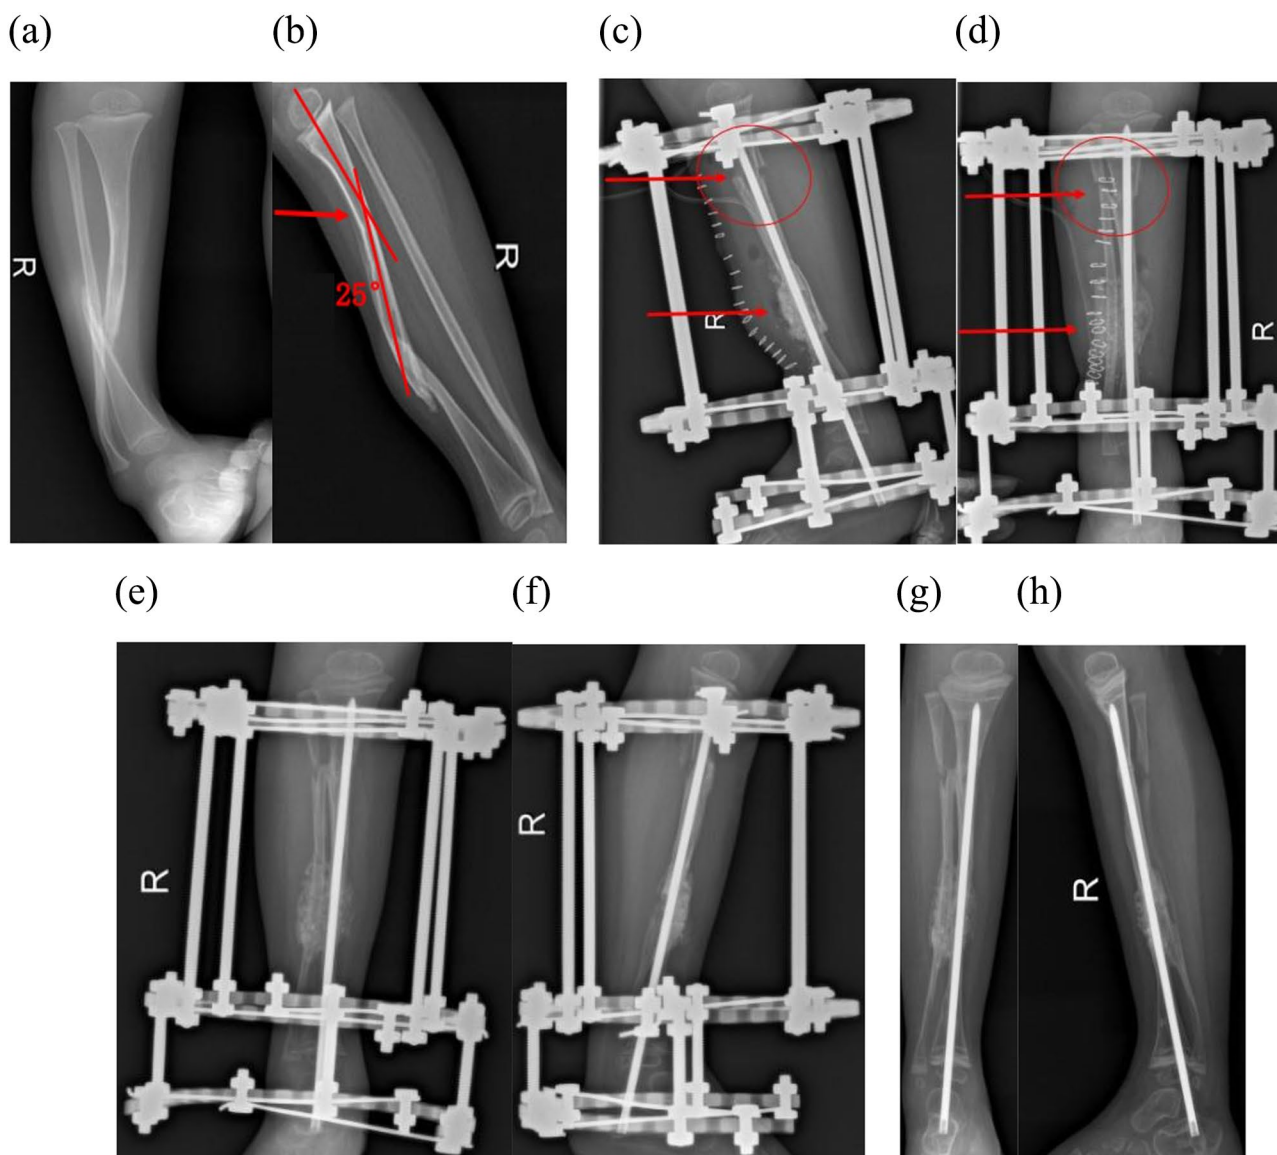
(a, b) CPT with proximal tibial dysplasia, male, 16 months old, preoperative anteroposterior and lateral X-ray. (c, d): One week postoperative anterior and lateral X-rays of the tibia and fibula. (e, f): At 4 months and 9 days post-surgery, anterior and lateral X-rays of the tibia and fibula were obtained. (g, h): At 14 months post-surgery, the anterior and lateral X-rays of the tibia and fibula revealed good positioning of the intramedullary rod
